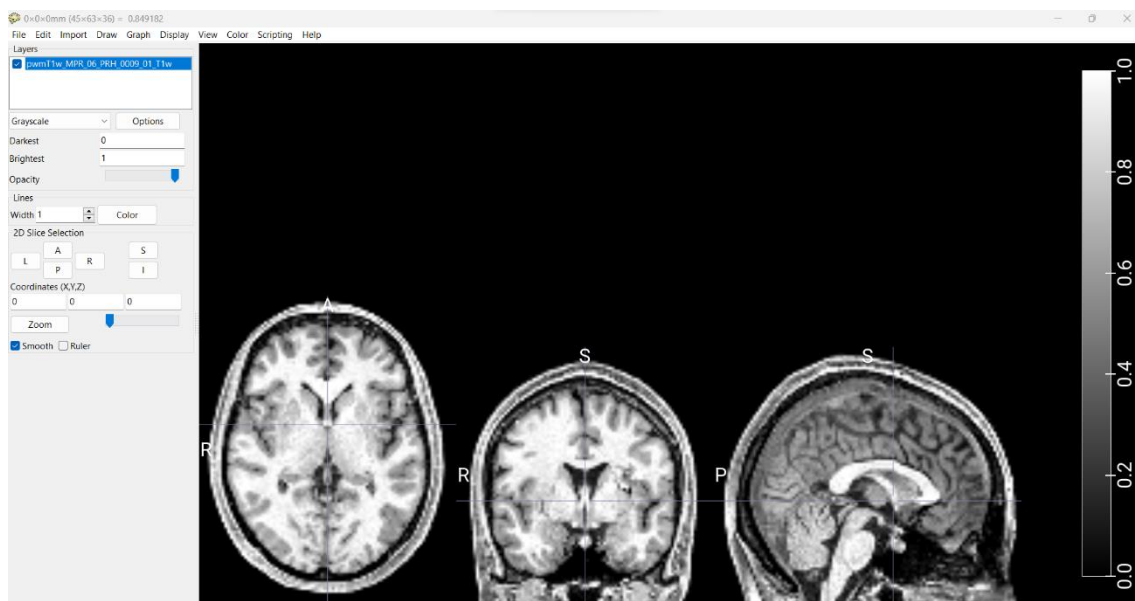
Structural MRI in MNI space.
